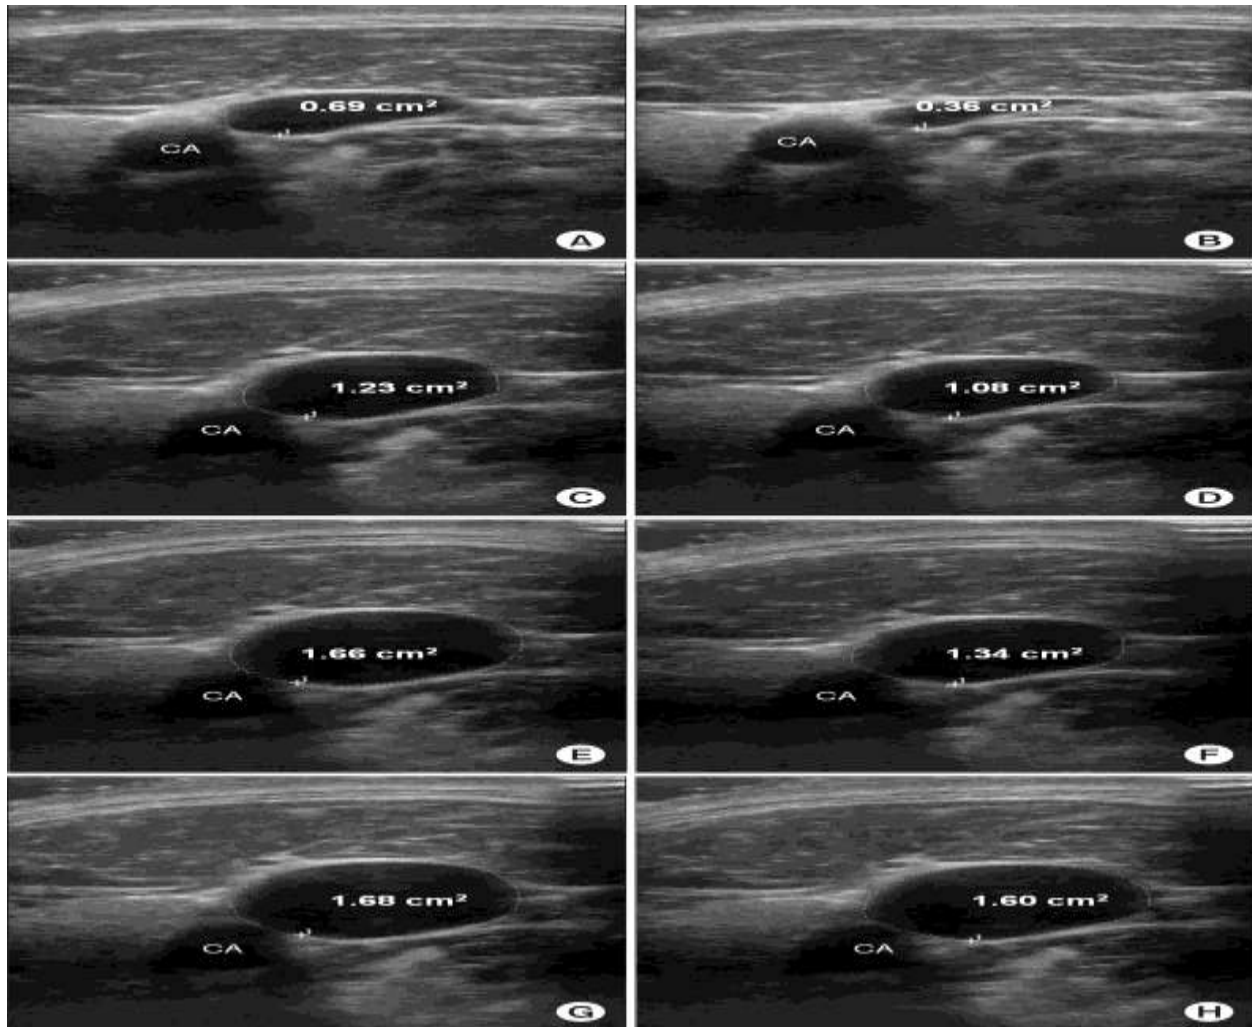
Ultrasound images of the right internal jugular vein from one patient in four different maneuver combinations for the largest and smallest sizes recorded.
